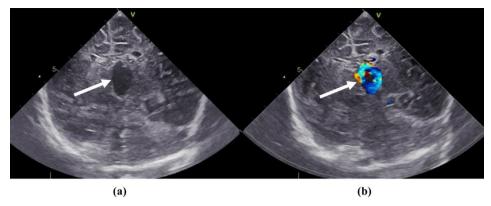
(a) Axial bran sonogram of Case 1 showing a cystic intracranial echo-free area (dilated vein of Galen) and (b) Doppler assessment revealing prominent turbulent blood flow with a low resistance waveform.
